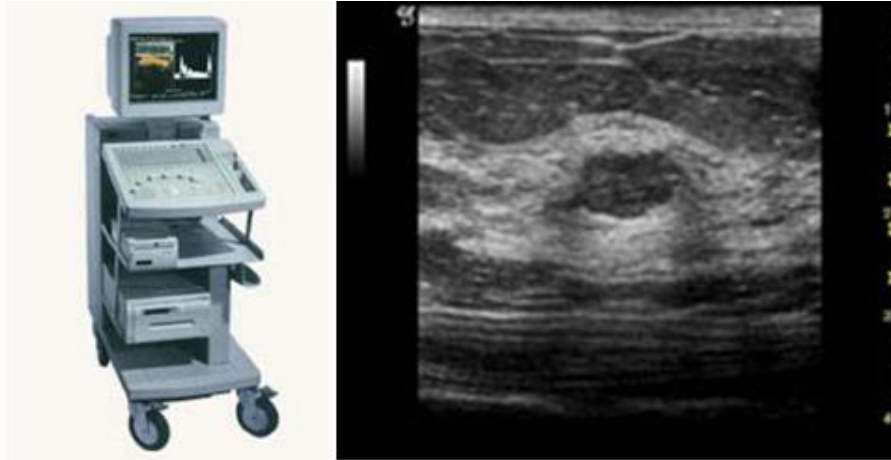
The Sonography equipment and a Sonography image that show a cluster of small calcifications that may indicate that cancer is present.<sup>209,210</sup>
